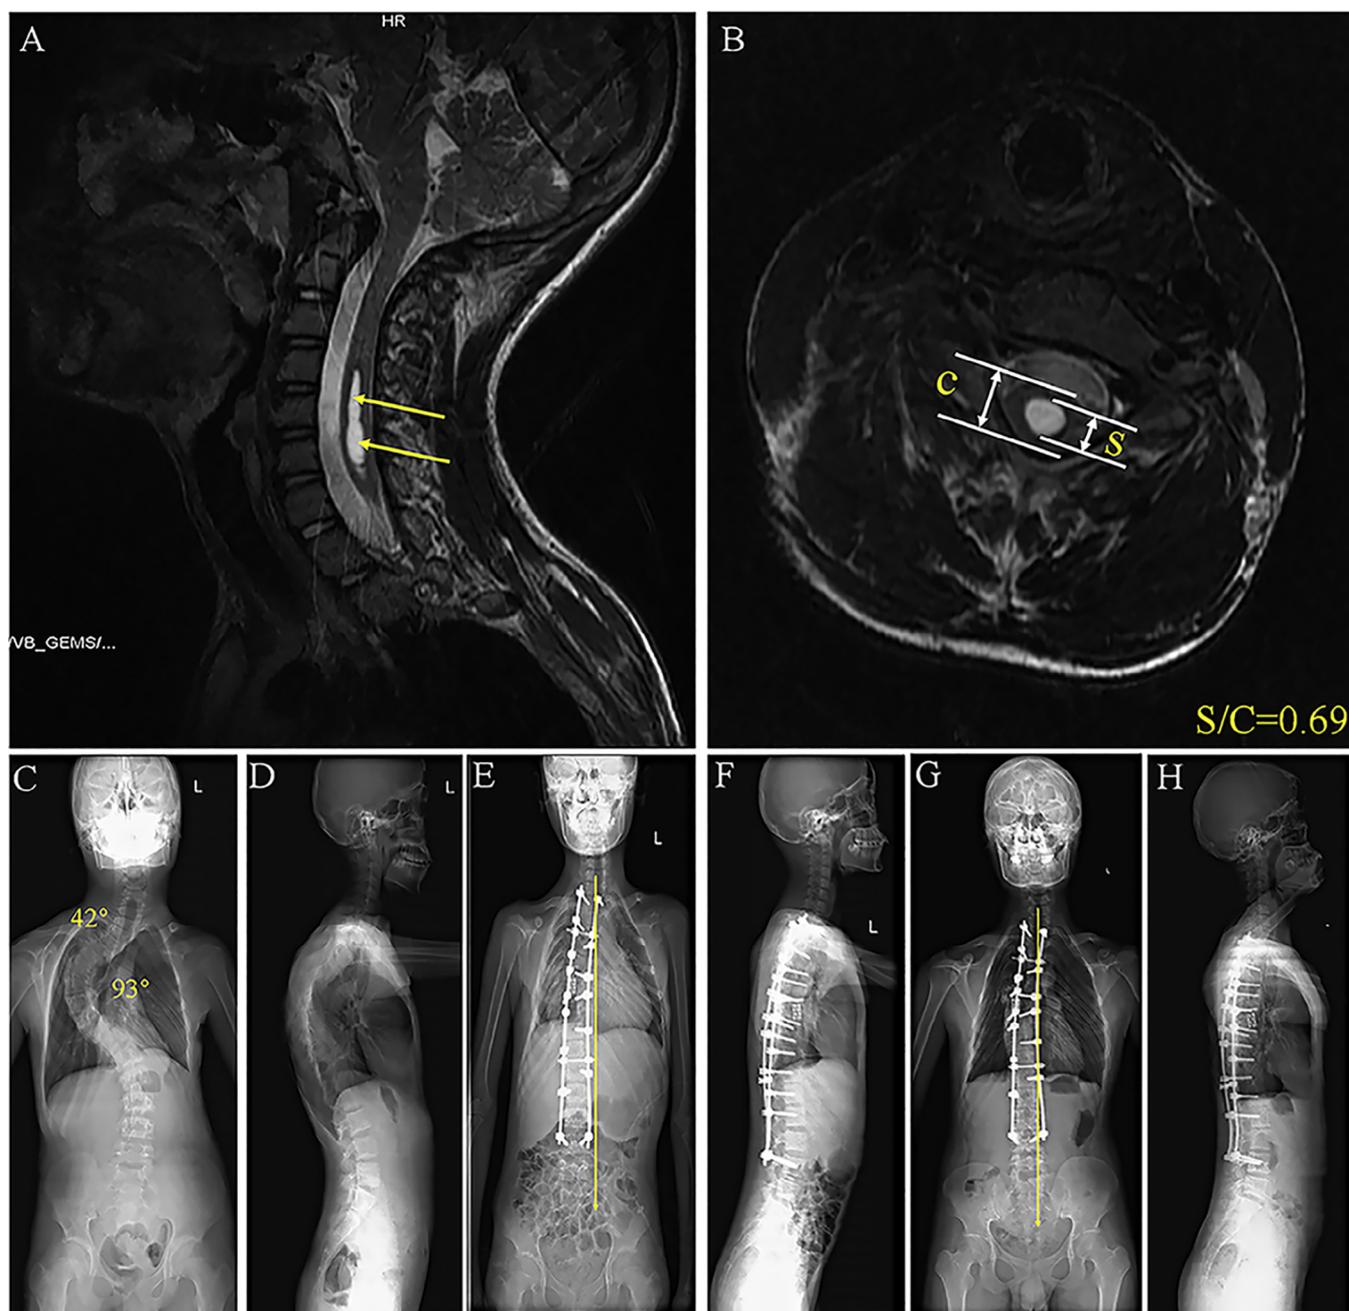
A 15-year-old boy with a severe and rigid thoracic curve associated with syringomyelia (C, D). The radiographs demonstrate a thoracic curve of 93° and a cranial curve of 42° , the syrinx, with a syrinx/spinal cord (S/C) ratio of 0.6 and a length of 3.5 vertebrae (A, B), and postoperative posteroanterior (E) and lateral (F) radiographs following posterior spinal fusion from T2 to L4 demonstrate coronal imbalance of 30 mm. Radiographs made 6 years after surgery (G, H) reveal well-maintained global coronal and sagittal balance.
